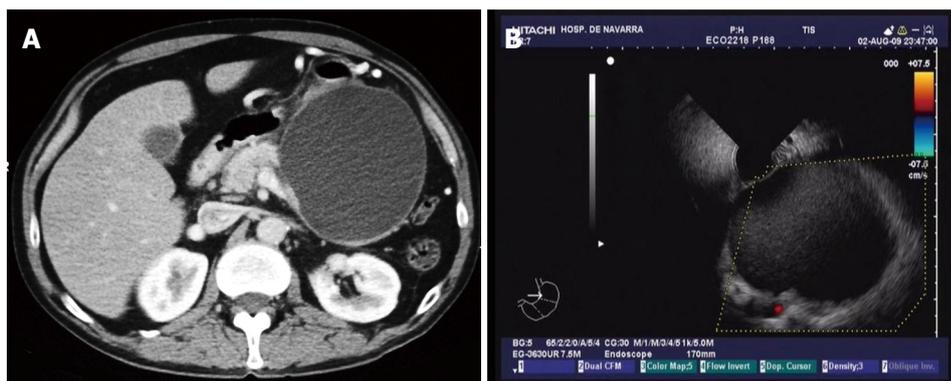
Images of a 14 cm diameter pseudocyst in a patient with an alcoholic chronic pancreatitis. A: CT; B: Endoscopic ultrasonography (EUS) with doppler, the pseudocyst can be seen in close contact with the gastric wall without intervening vessels.
